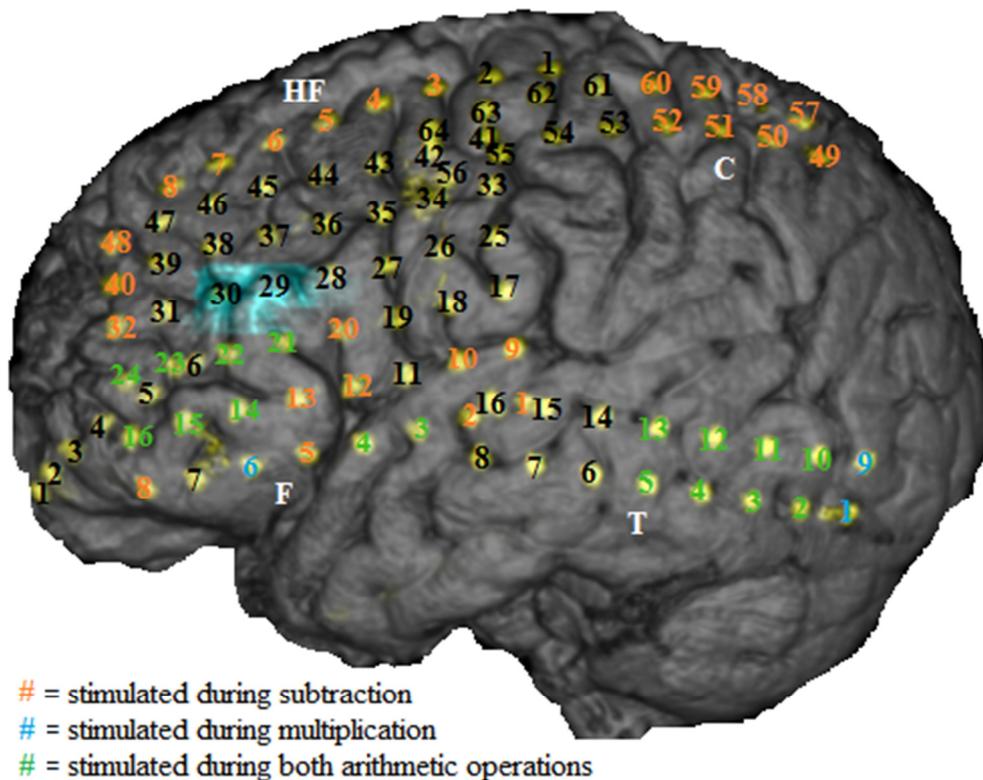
MRI of patient N.V. with numbers and locations of the temporarily implanted electrodes (left hemisphere). The electrodes with orange numbers were stimulated during subtraction, the electrodes with blue numbers were stimulated during multiplication, and the electrodes with green numbers were stimulated during the examination of both arithmetic operations. Electrodes F1-6, F8-10, F 12-16 and F20-24 are situated on the inferior frontal gyrus, including Broca's area. Electrodes F32, F40 and F48 are localized on the middle frontal gyrus, and electrodes HF3-8 are situated on the superior frontal gyrus. Electrodes T1-5 and T9-13 are situated on the superior temporal gyrus, including Wernicke's area. Electrodes C49-52 and C57-60 are localized on the superior posterior parietal lobe. The blue area represents the epileptic focus.
